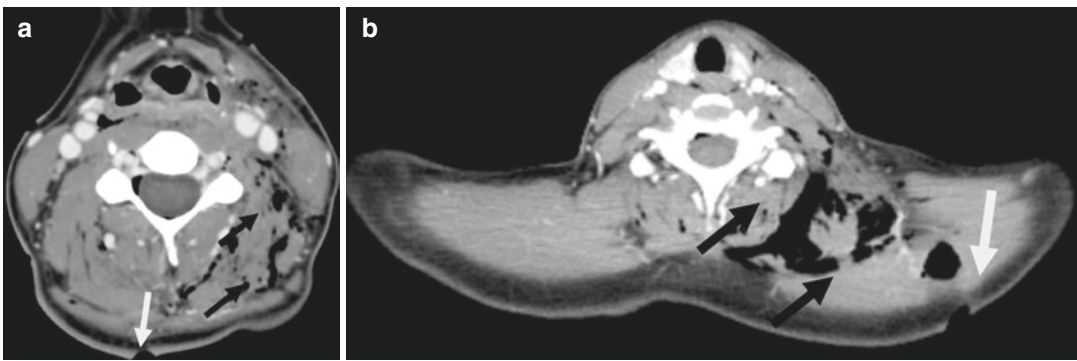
(a) Axial CT scan; arrows are pointing at air and haematoma at the wound site (white arrow), delineating the wound track (black arrows). (b) Same patient. Axial
